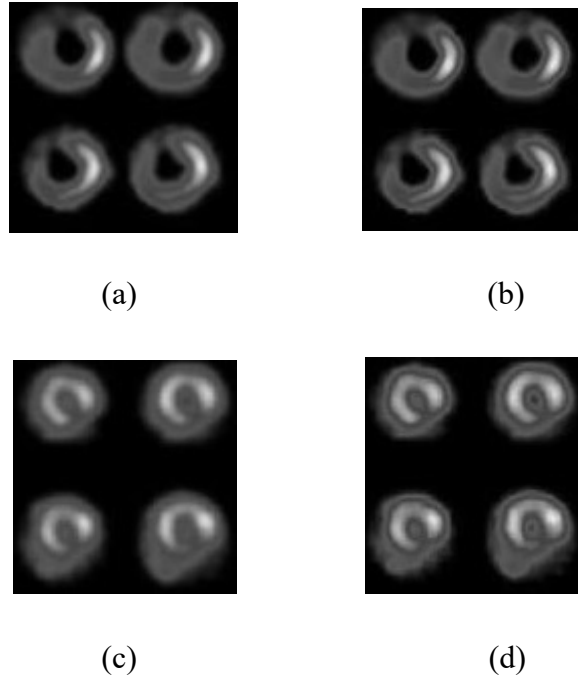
(a) Cardiac SPECT image blurred using a Gaussian PSF with $\sigma=7$ (b) Deblurred image using the proposed method (c) Normal blurred image (d) Deblurred image
